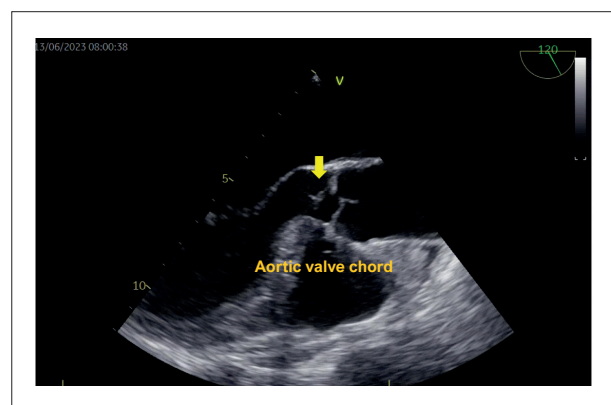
Transesophageal echocardiogram at 120°, showing a filamentary lesion related to the ventricular surface of the aortic valve, markedly mobile and measuring up to 21mm.
